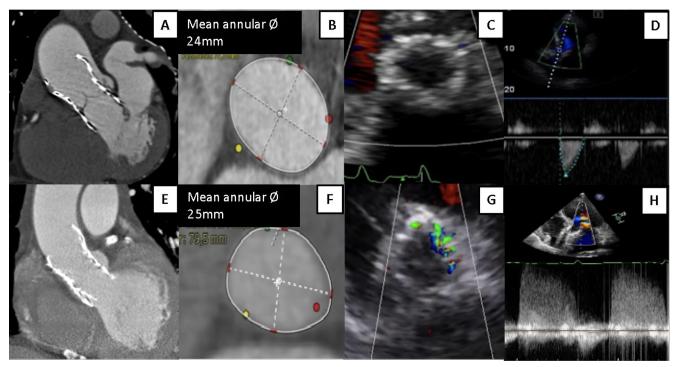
TOP: Panels A, B, C, D correspond to a patient without PVL after implantation of an Evolut PRO #29. Panel A. coronal CT image post TAVR shows mild oversizing with respect to the aortic annulus. Panel B. oblique transverse CT view showing a mean aortic annular diameter of 24 mm. Panel C. color Doppler in short axis view at the pre-discharge transthoracic echocardiography with no PVL. Panel D. Continuous wave Doppler through the aortic valve without any diastolic signal. BOTTOM: Panels E, F, G, H correspond to a patient with grade II PVL after implantation of a Evolut PRO #29. Panel E. coronal CT image post TAVR shows that TAVR is not oversized with respect to the aortic annulus. Panel F. oblique transverse CT view measuring a mean aortic annular diameter of 25 mm. Panel G. color Doppler in short axis view at the pre-discharge transthoracic echocardiography depicting a color jet around the aortic annulus of grade II PVL. Panel H. Continuous wave Doppler through the aortic valve with a continuous diastolic signal caused by the PVL.
